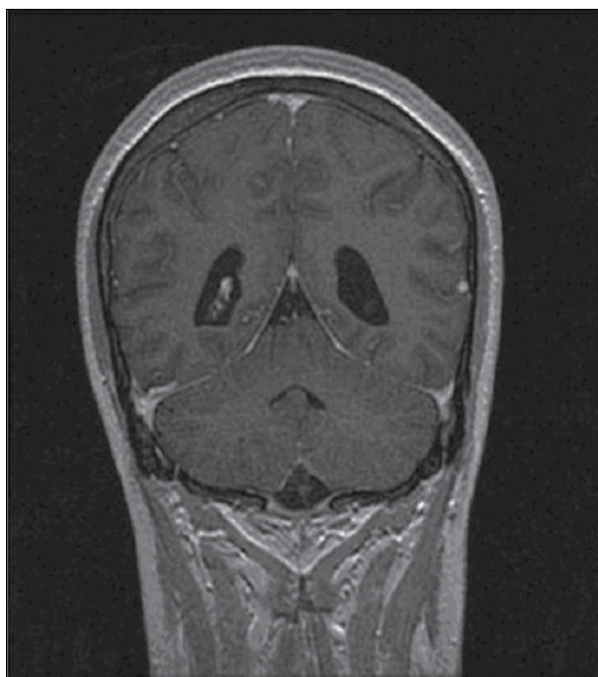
Coronal T1-weighted MRI showing the presence of a septum within the fourth ventricle and diffuse arachnoid enhancement in the medulla oblongata, pons and cerebellar hemispheres.
